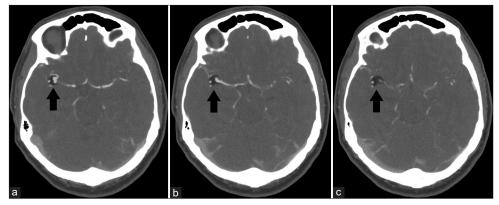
Non-contrast head CT scan in axial projections showing 3 consecutive scans 2,5 mm apart. The black arrow on images (a-c) show a cross-section at different levels of the lesion located in the right Sylvian fissure corresponding to a lipoma and encasing the right MCA. CT: Computed tomography, MCA: Middle cerebral artery.
